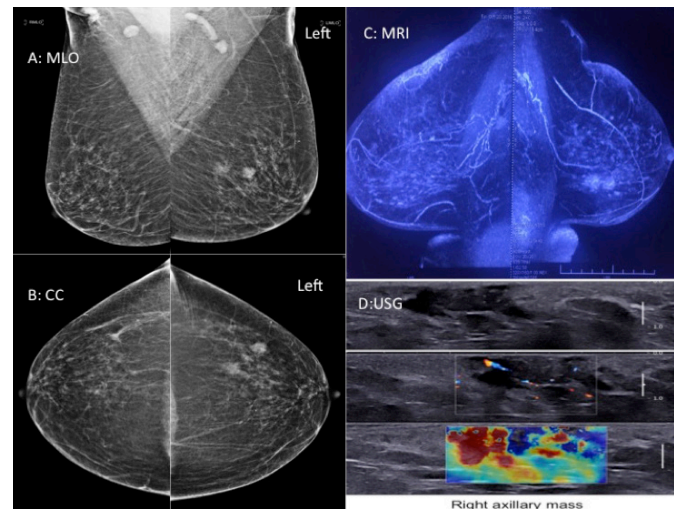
Depicts the imaging of the patient. A: Mediolateral oblique view of the mammogram showing clustered microcalcification with mass lesion in lower outer quadrant of left breast and skin thickening in right axilla. B: Cranio caudal view of the mammogram showing two suspicious mass like lesion in left breast. C: MRI bilateral breasts showing two suspicious lesions in left breast. D: USG with elastography right axilla showing suspicious right axillary mass
